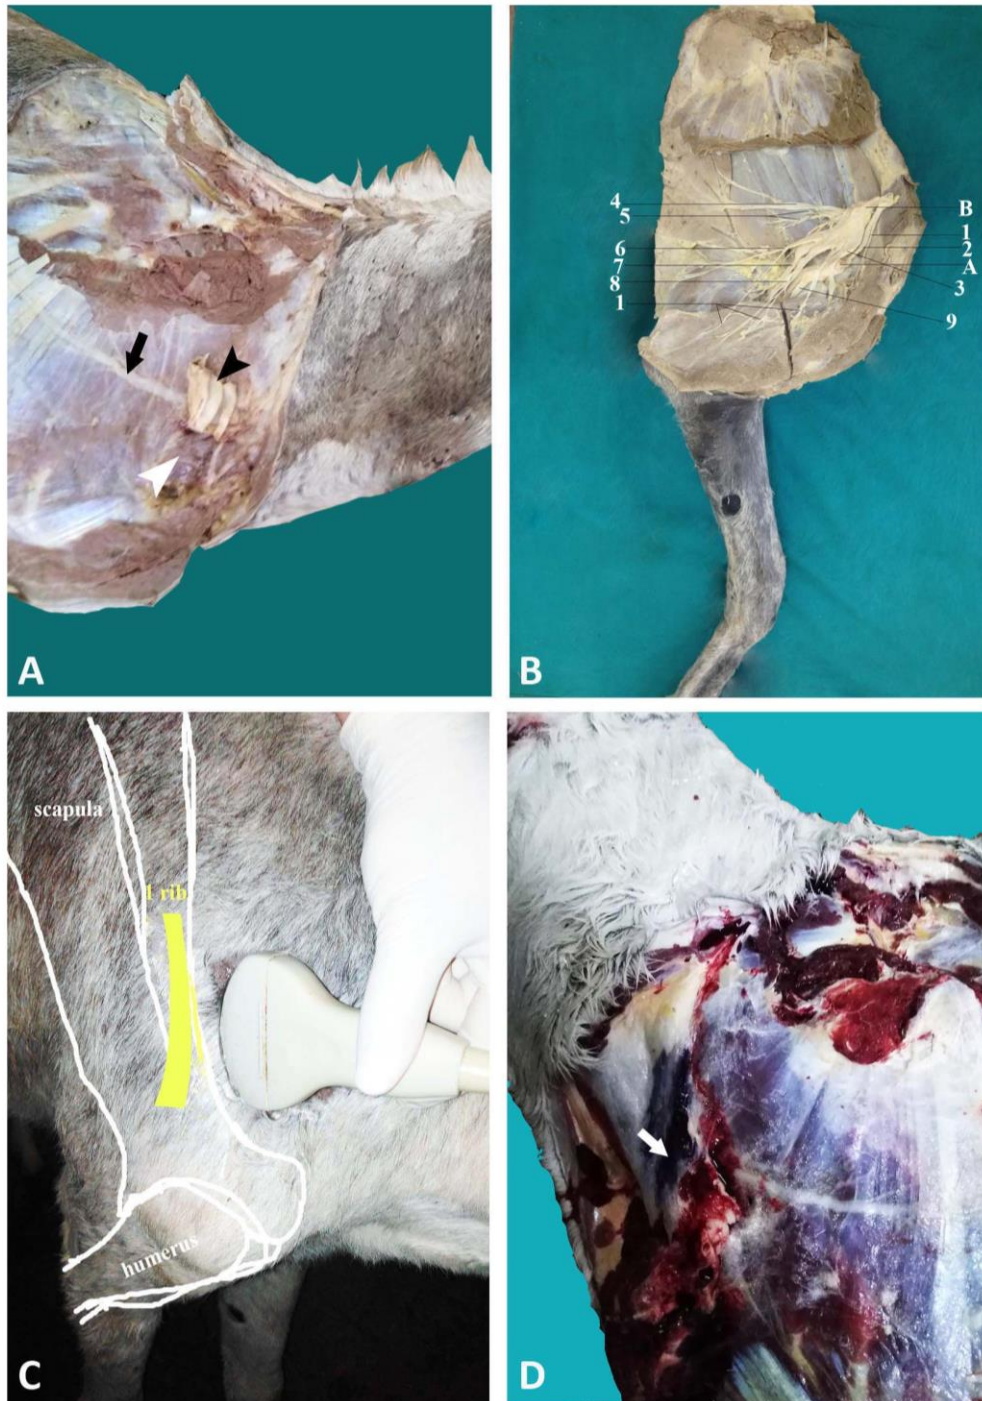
Position, branches of brachial plexus and site of ultrasound transducer. A. Position of brachial plexus (black arrowhead), scalenius medius muscle (white arrowhead) and long thoracic nerve (black arrow). B. Axillary artery (A) surrounded by branches of brachial plexus (B); pectoral nerves (1), musculocutaneous nerve (2), median nerve (3), dorsal thoracic nerve (4), subscapular nerve (5), lateral thoracic nerve (6), radial nerve (7), ulnar nerve (8) and the musculocutaneous with median nerves (9). C. Position of ultrasound transducer in front of cranial border of scapula and first rib and dorsal to the shoulder joint. D. Site of injection of methylene blue dye (white arrow) in the region of brachial plexus
